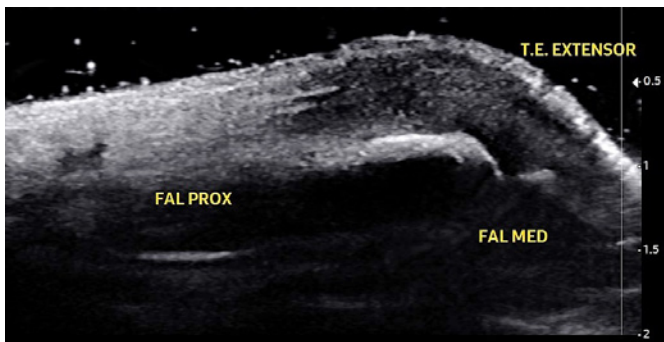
B-mode ultrasound showing the extensor apparatus of the third finger as hypoechoic, thickened, and with loss of the normal fibrillar pattern.
